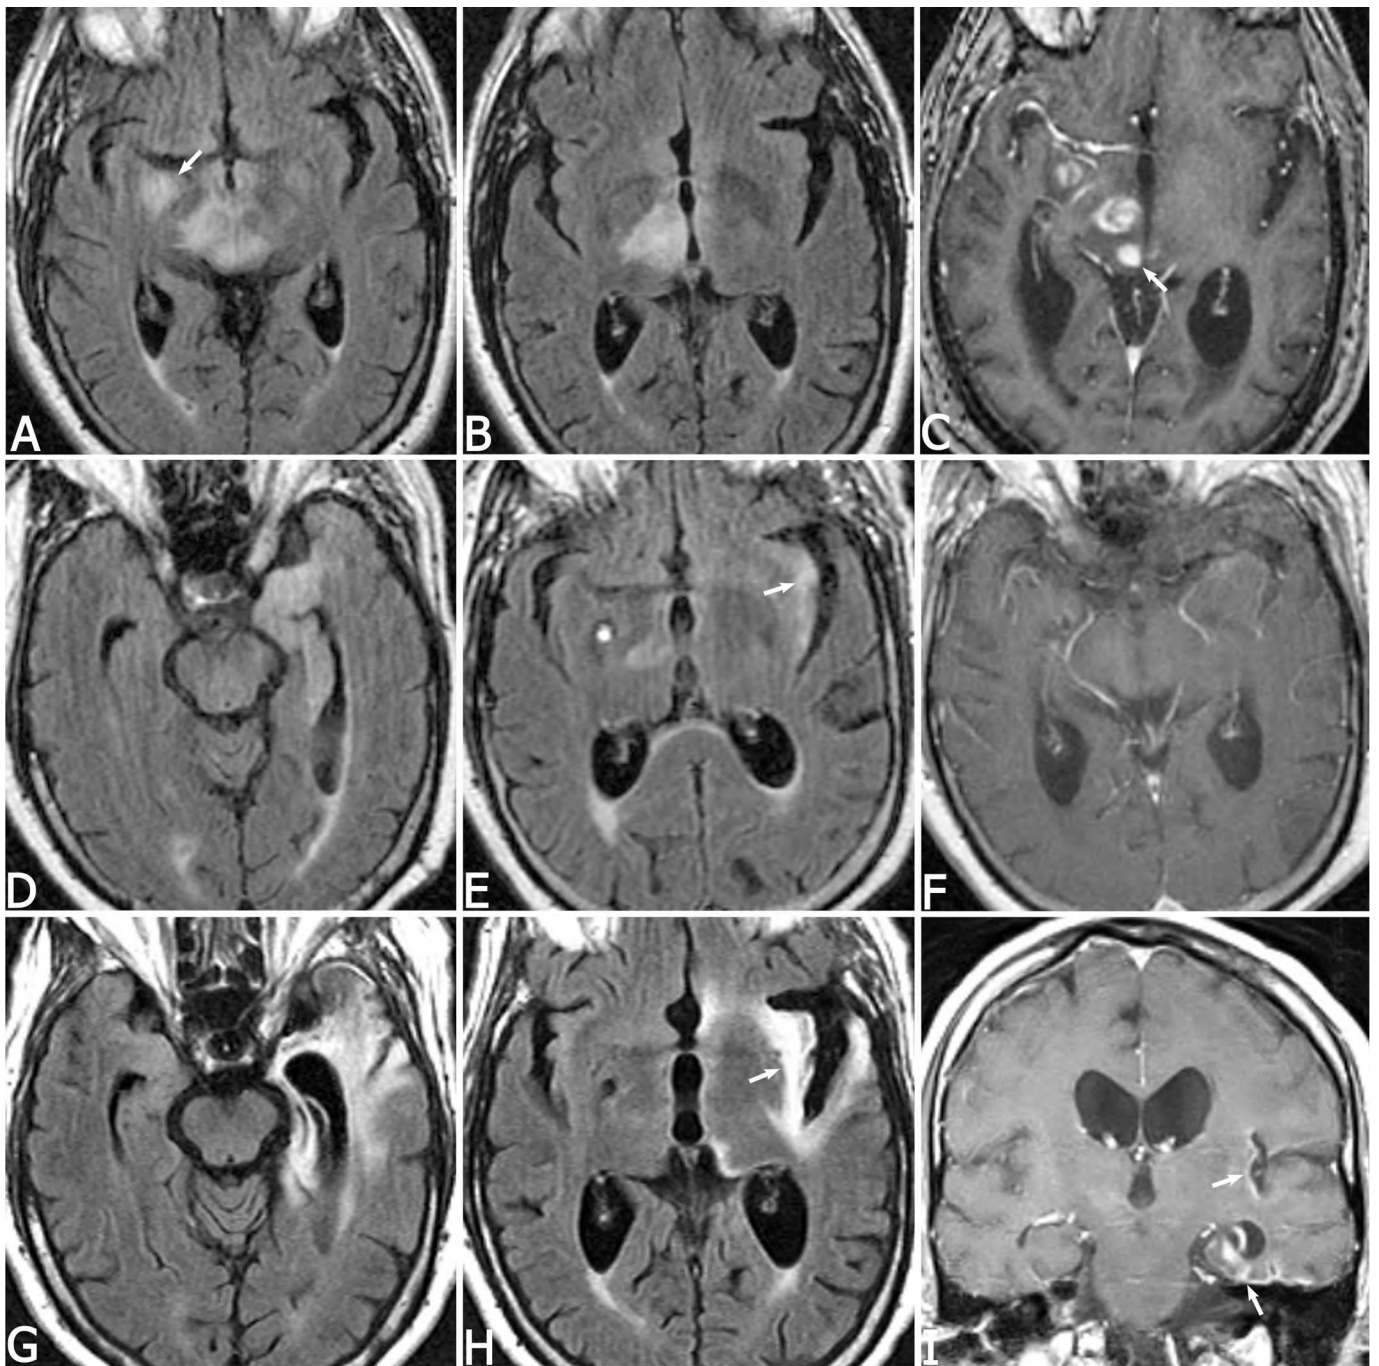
Brain MRI at diagnosis and follow-up. (A through C) MRI at time of paraneoplastic neurologic disorder diagnosis (April 2000). Axial fluid-attenuated inversion recovery (FLAIR) images (A and B) show abnormal hyperintensity in the midbrain, right mesial temporal lobe (arrow), and right thalamus. Axial contrast-enhanced T1 magnetic resonance (MR) image (C) from the patient's stereotactic MRI shows abnormal enhancement in the right thalamus, superior colliculus (arrow), and right mesial temporal lobe. (D through F) MRI at time of herpes simplex virus encephalitis (May 2000). Axial FLAIR images (D and E) show abnormal hyperintensity in the left mesial temporal lobe and insular cortex (arrow) consistent with the diagnosis of herpes encephalitis. The focal abnormal signal intensity in the right mesial temporal lobe is related to previous biopsy. Note the near resolution of abnormal hyperintense signal in the right mesial temporal lobe, midbrain, and thalamus. Contrast-enhanced axial T1 MR image (F) shows resolution of the previously seen enhancement in the right mesial temporal lobe, superior colliculus, and thalamus. (G through I) MRI showing the chronic effects of herpes encephalitis (December 2000). Axial FLAIR MR images (G and H) show extensive abnormal hyperintense signal in the left temporal lobe and insular cortex (arrow). There is temporal lobe volume loss with associated compensatory dilatation of the left temporal horn of the lateral ventricle and sylvian fissure. Contrast-enhanced coronal T1 MR image (I) shows abnormal T1 shortening related to blood products and subtle enhancement in the left insular cortex and temporal lobe (arrows) related to the patient's previous herpes encephalitis. Note the lack of significant enhancement of the right temporal lobe, midbrain, and thalamus.
